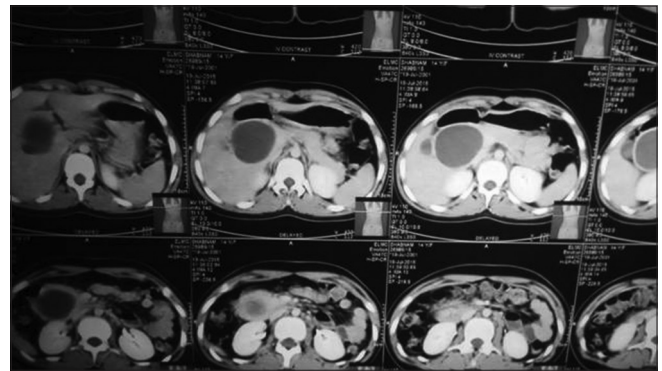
Contrast-computed tomography films
